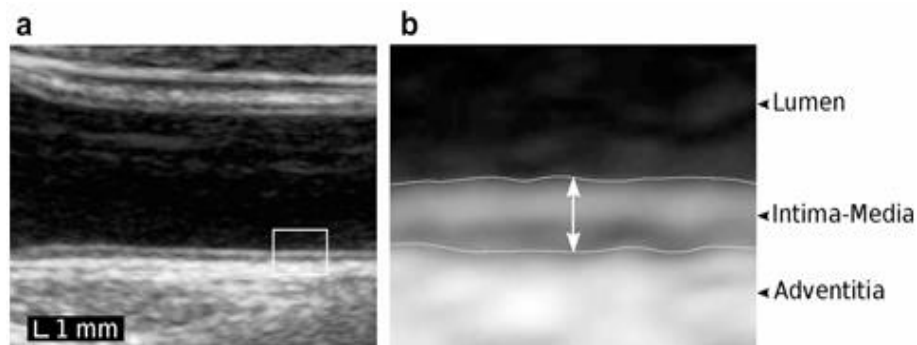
1: *a.* Longitudinal view of the common carotid artery in B-mode ultrasound imaging, *b.* enlarged region detailing the intima–media complex (Zahnd et al., 2015b).
